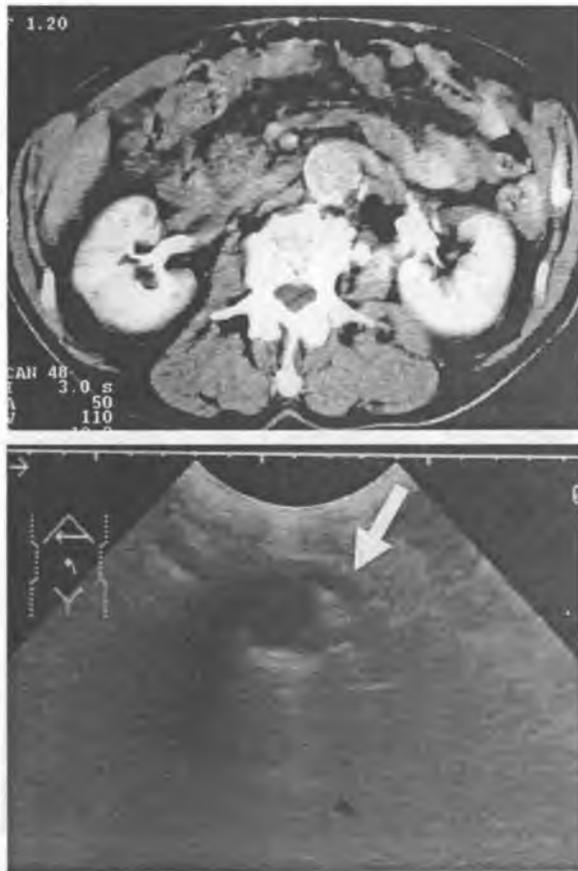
Renal artery visible on both CT (A) and ultrasonographic (B – arrow) images
